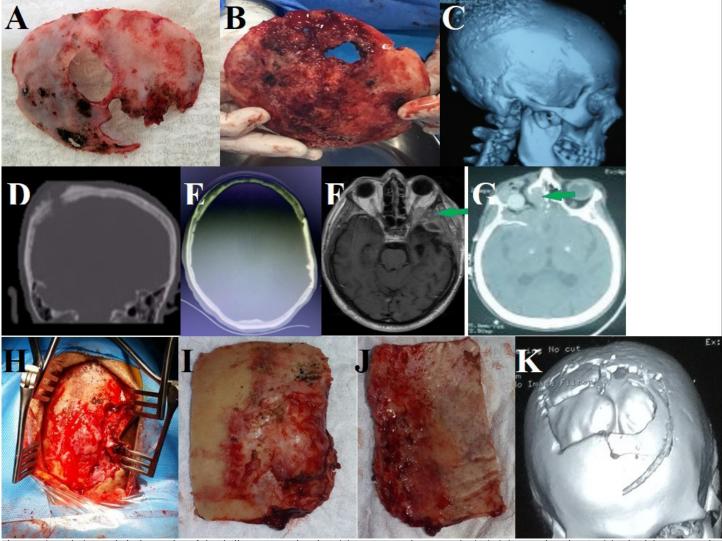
(A and B) Osteolytic destruction of the skull. Intraoperative view; (C) 3D computed tomography (CT); (D) coronal section CT; (E) calvarial reconstruction using polymethyl methacrylate cement on axial section CT; (F, G) residual mass on MRI and CT; and (H–K) large calvarial defect with parietal tumor
